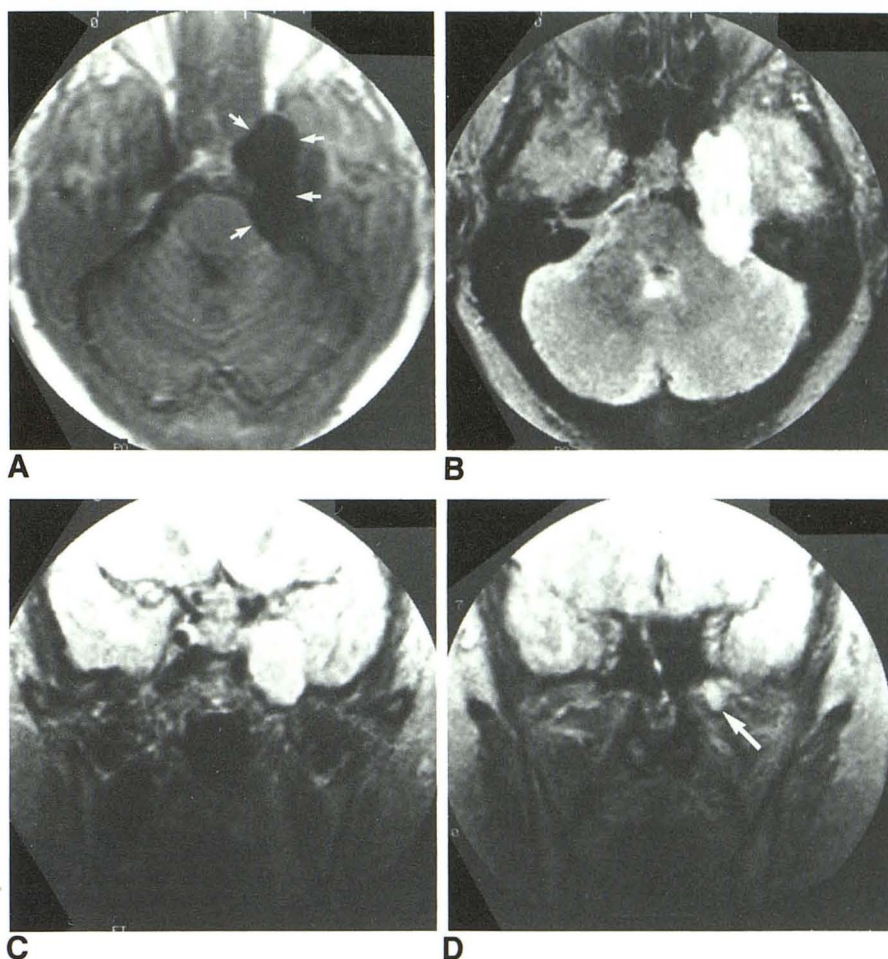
A–C, Case 2. Trigeminal schwannoma of right gasserian ganglion with smooth margins, relatively low signal intensity (arrows) on T1-weighted image (A, 2100/600/40), and high heterogeneous signal intensity on T2-weighted image (B, 2300/80); C, 1650/120. Note normal Meckel's cave (curved arrow) on left in C.
